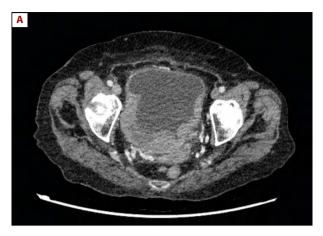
Computed tomography of the pelvis with contrast. There is evidence of irregular thickening of the posterior and lateral walls of the bladder
